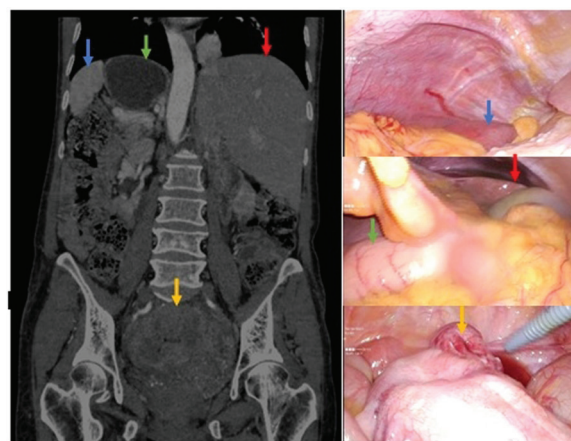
(A) CT scan image and (B) laparoscopic image showing the spleen (blue arrow), gastric cardia (green arrow), right liver lobe (red arrow), and rectal mass (yellow arrow). PGH, 2022.
